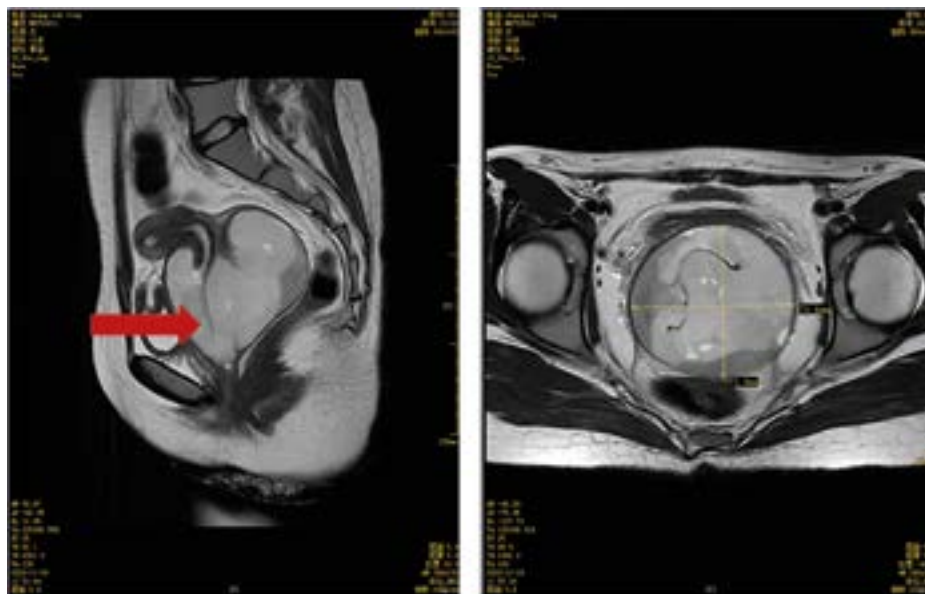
Magnetic resonance images of Patient 6: mixed signal mass in the external cervix and vagina
